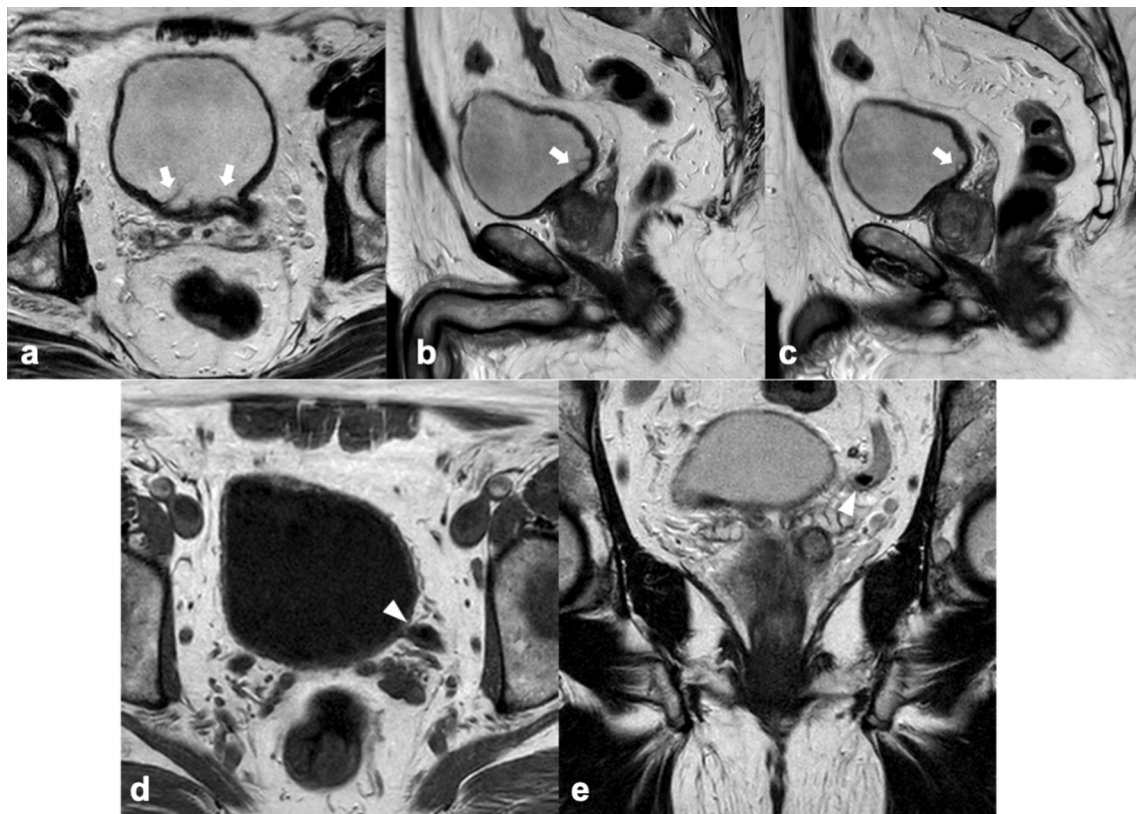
Axial (a) and sagittal T2w images (b-c) show bilateral cystic dilatation of the terminal ureter at its opening into the bladder (arrows), in keeping with ureterocele. Axial T1w (d) and coronal T2w (e) images show a dilated left ureter with a juxta-vesical hypointense stone (arrowheads). T2w T2-weighted, T1w T1-weighted.
